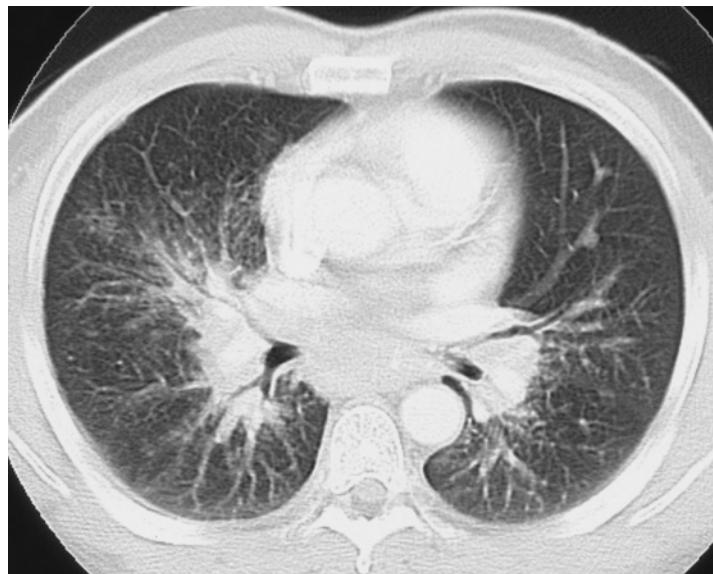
CT scan of review case 2: perihilar shadowing with bronchovascular nodules in stage IIa sarcoidosis.
